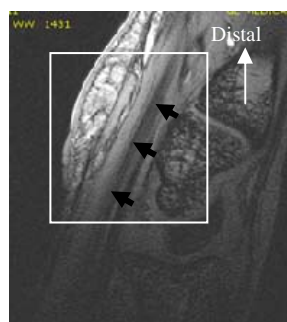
Median nerve at sagittal MR image (black arrows)
